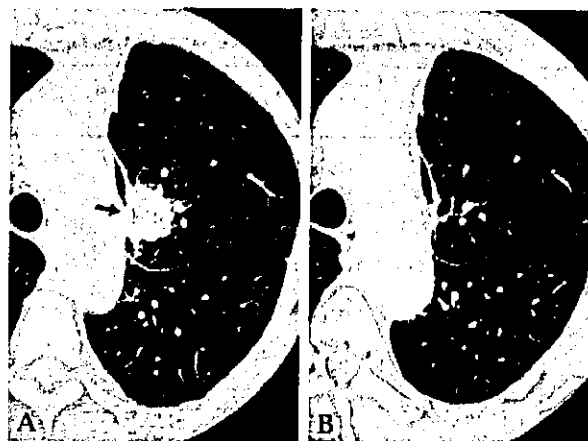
On the CT findings, one patient (case 6) suffered from margin relapse, which developed adjacent to resected staple line (arrow), 4 years after initial resection (A). About 8 months later, spontaneous resolution of the tumor has been observed (B).
